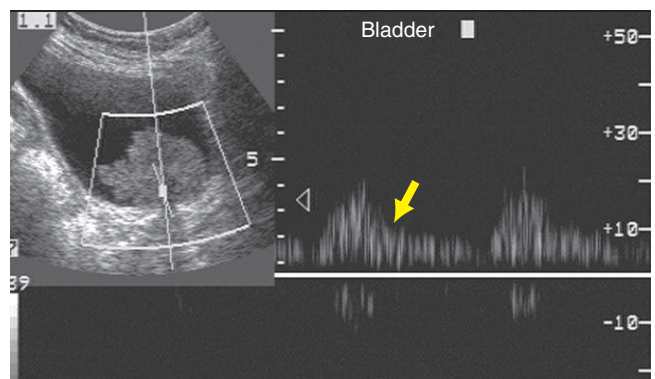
Pulse Doppler waveform through the mass demonstrating arterial flow (arrow).
